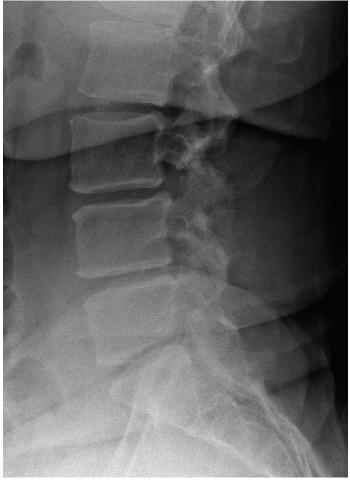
Pre-operative Lateral View X-ray of the Lumbar Spine.
